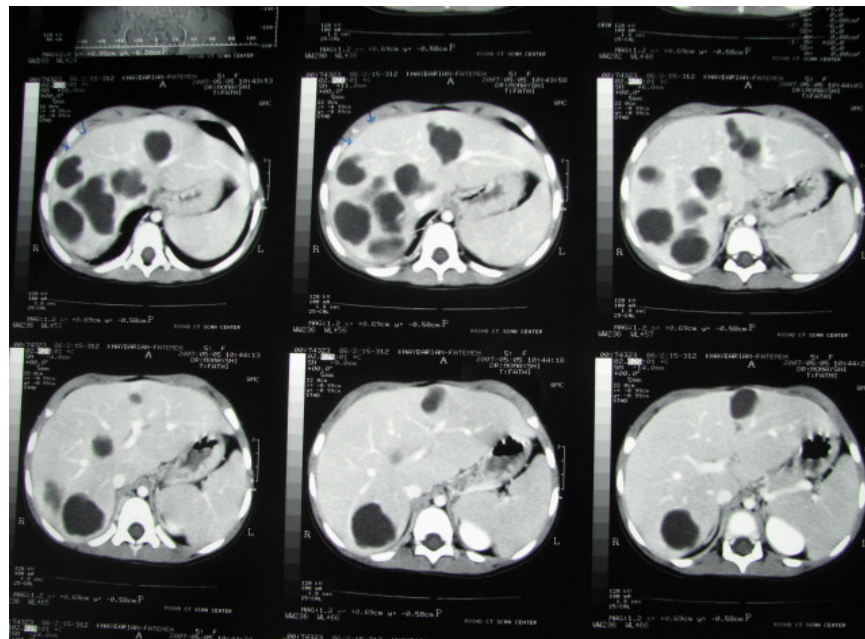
Abdominal CT scan of the patient
